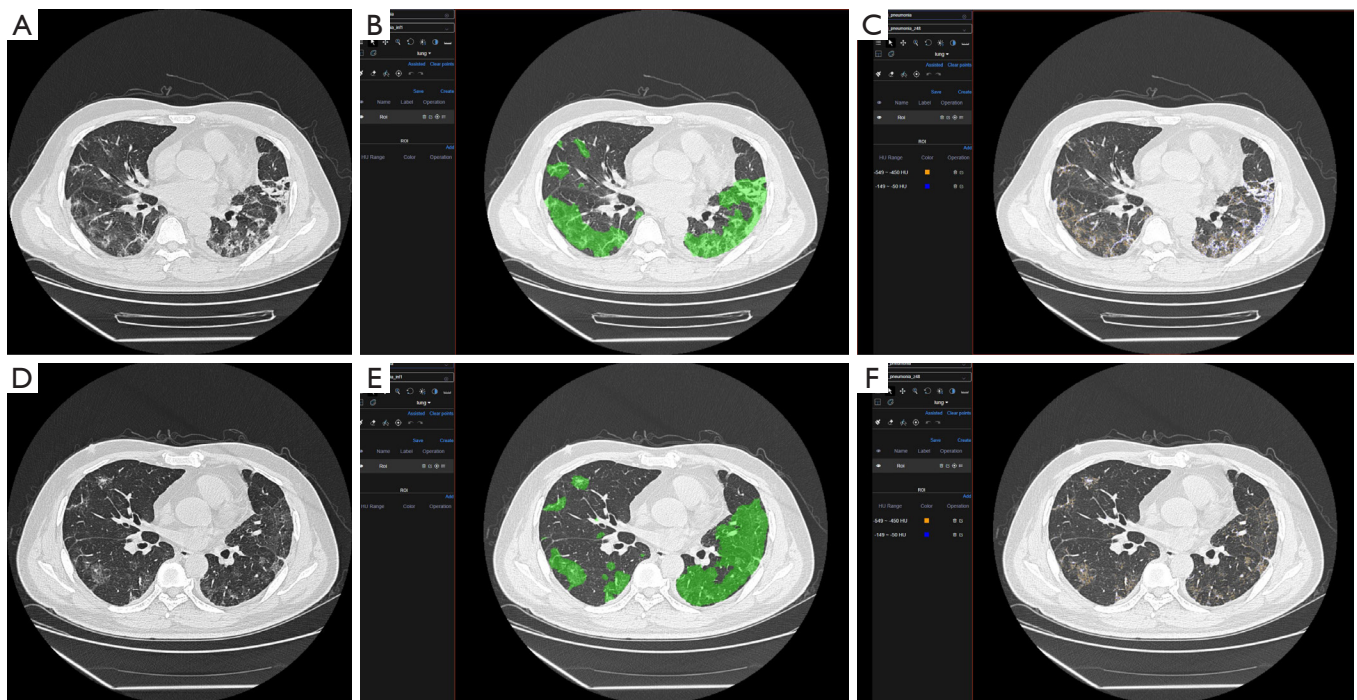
A 56-year-old male was diagnosed with severe COVID-19, which had an extensive infection in the bilateral lung. Interestingly, his respiratory status stayed fine during the whole treatment. (A,B,C) was the first CT scans after admission. (D,E,F) was the CT scans after seven days treatment. In both CT scans' quantitative analysis, zone 4 only composed of a limited proportion of the whole infection area. COVID-19, coronavirus disease 2019; CT, computed tomography.
